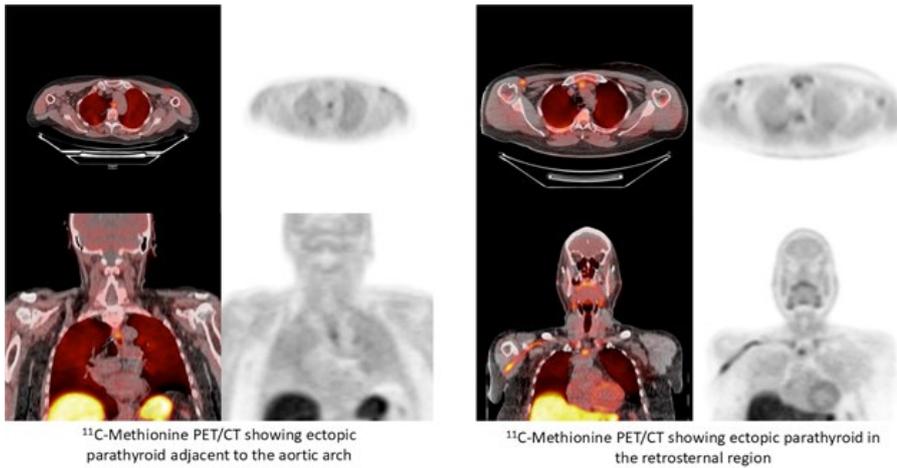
Ectopic sites detected with ¹¹C-Methionine PET/CT from the sample
